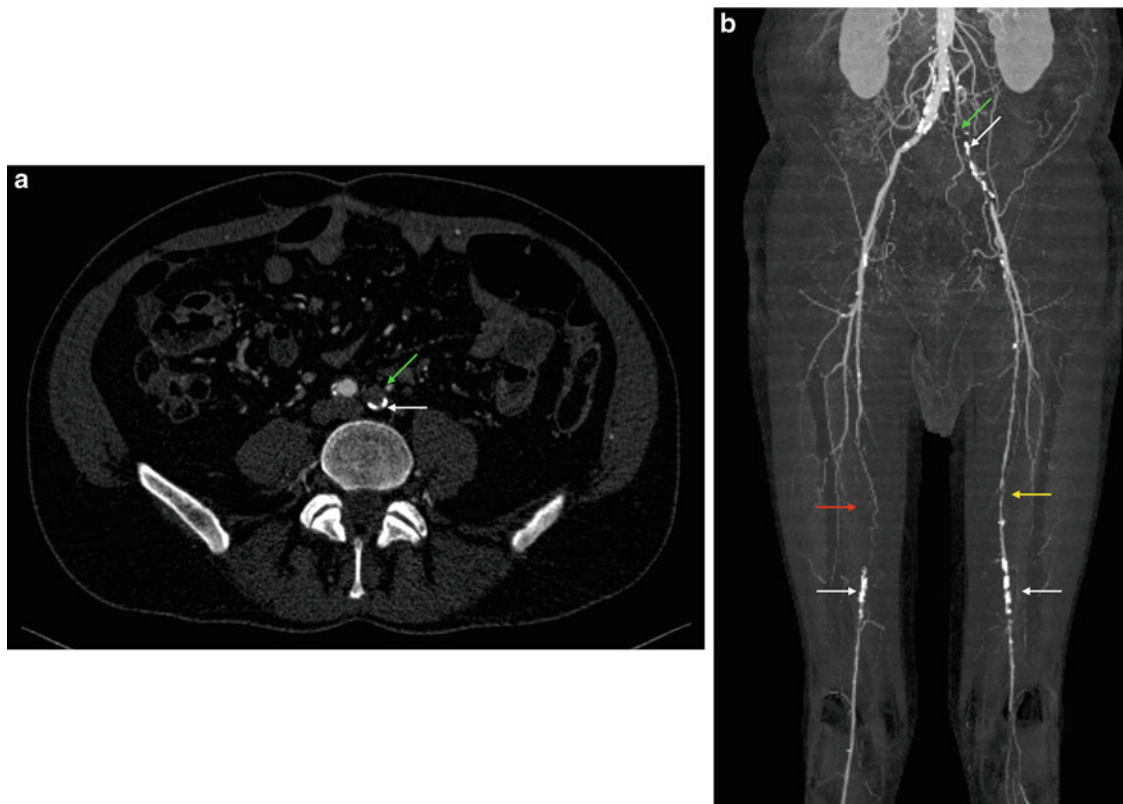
Computed tomography angiography. (a) Axial image showing a left iliac occlusion (green arrow) and (b) 3D reformat showing left iliac occlusion (green arrow), right superficial femoral artery (SFA)
